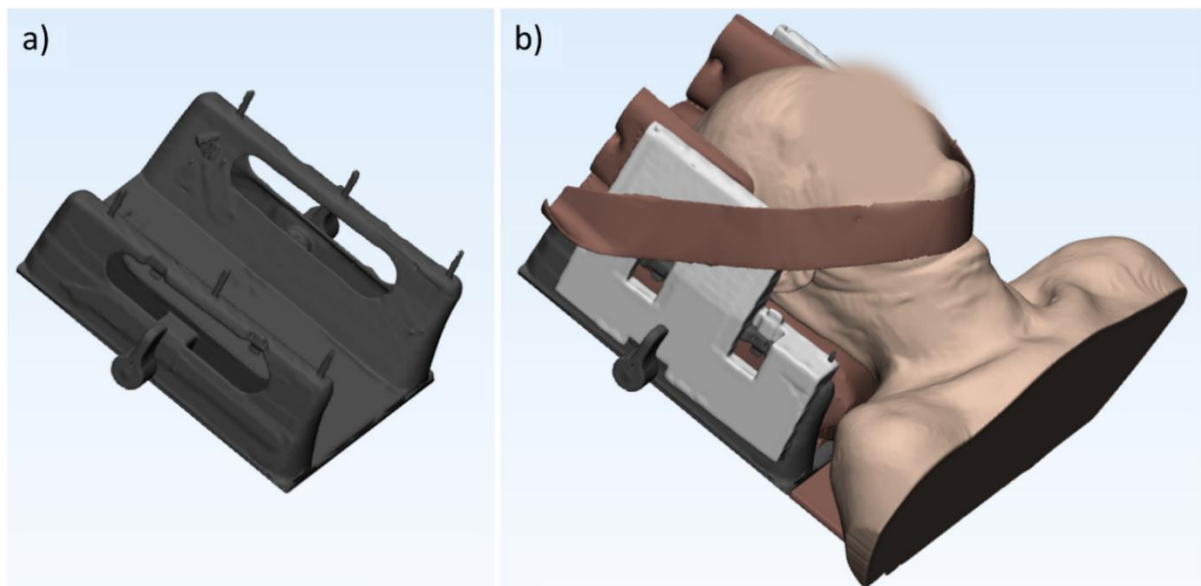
Patient position during acquisition of the study planning CT scan to obtain the body contour. The patient was positioned in supination on a treatment couch overlay (a) (visualized in dark grey), which forms part of a commercially available stereotactic RT head immobilization mask system. A foam mattress and a soft travel pillow were used as body support and headrest, respectively (visualized in brown) (b).
